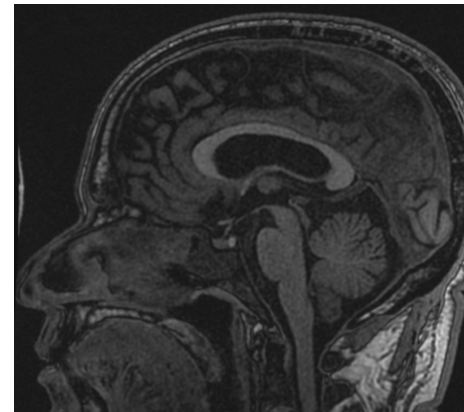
T1-weighted MRI in sagittal view post-contrast: unremarkable pituitary gland
